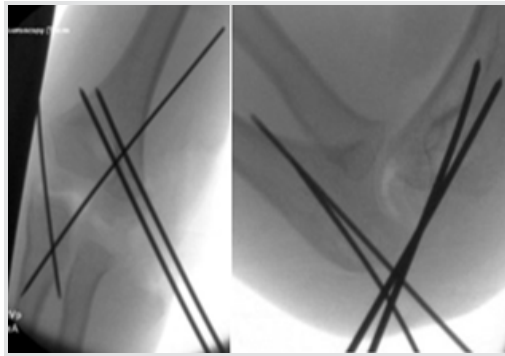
Anteroposterior and lateral view radiographs of the left elbow obtained by intraoperative fluoroscopy.
